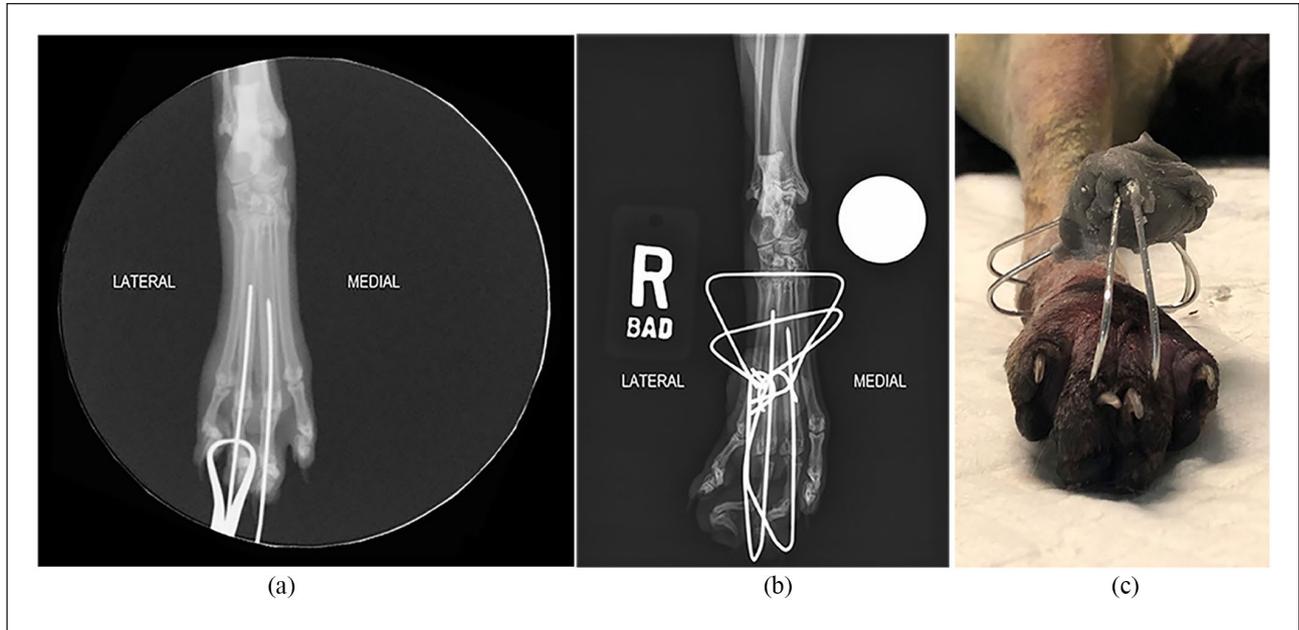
(a) Intraoperative craniocaudal fluoroscopic image of the pes of the right pelvic limb. The third, fourth and fifth metatarsophalangeal joints have been reduced. Digits III and IV are each stabilized with a transarticular and intramedullary Kirschner wire. (b) Postoperative craniocaudal radiographic image. Two transverse Kirschner wires have been placed and all four wires were bent to converge over the dorsal aspect of the pes. (c) Photographic image of the pes. A sphere of polymethylmethacrylate has been applied, which envelops the ends of all four Kirschner wires. Mild internal rotation of digits III and IV can also be observed
